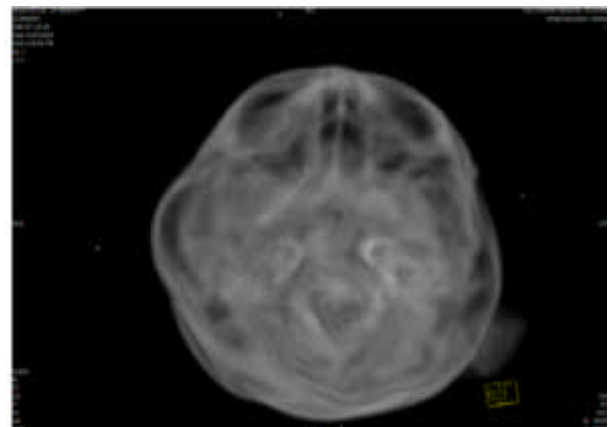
Axial CT scan image at the level of palate.
